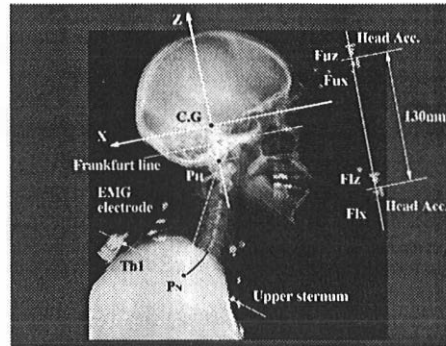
Coordinate system and lateral view of the head/neck/torso with mounted accelerometers, EMG electrodes, VTR targets and the marked points for X-ray picture
